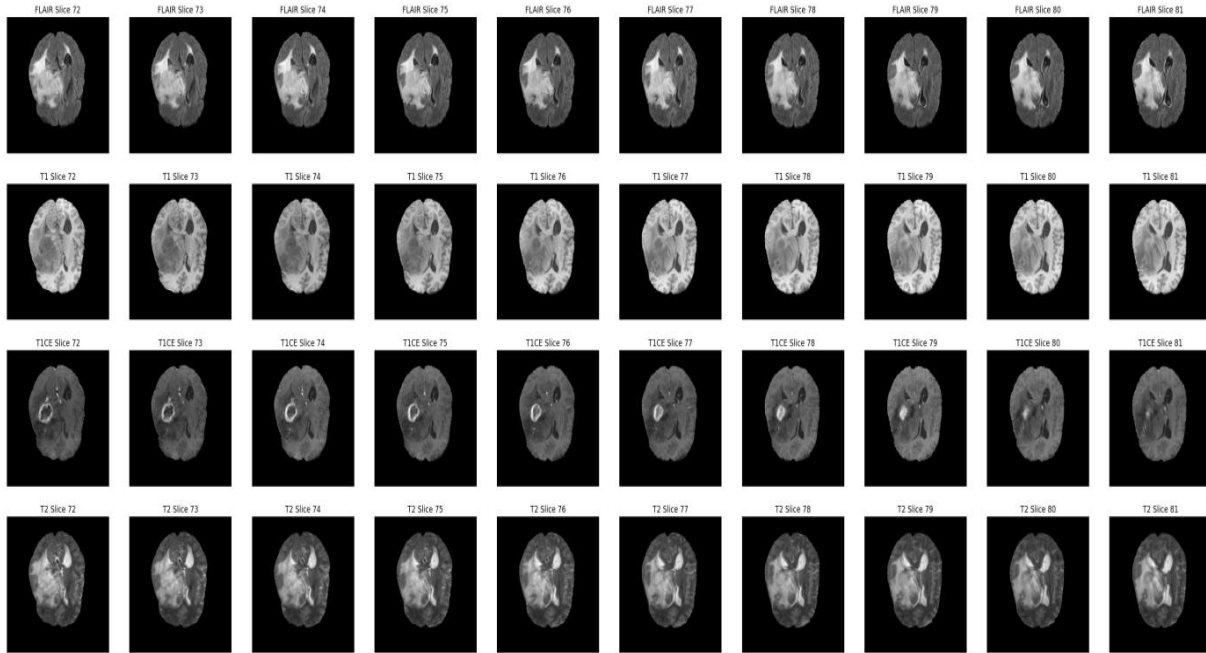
Middle slices visualization of multimodal brain MRI data.
